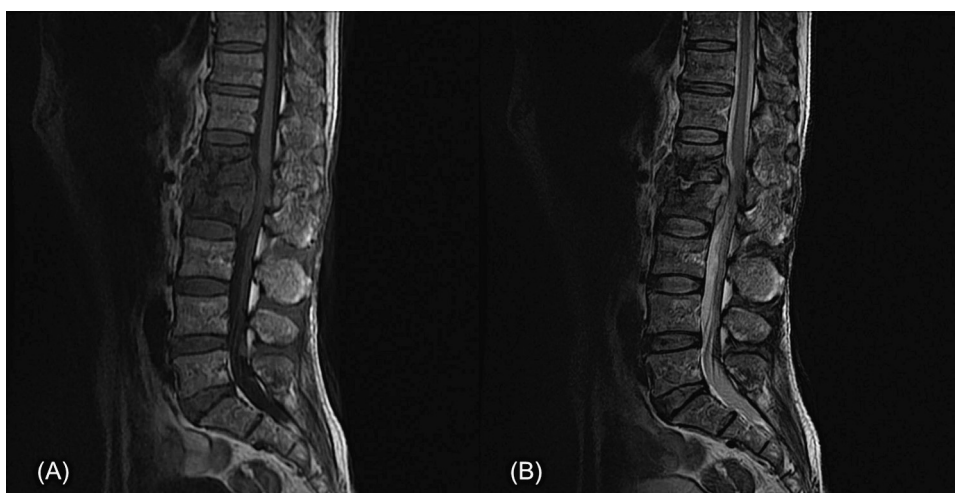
MRI scan of one patient with lumbar spinal tuberculosis showing that the L₁₋₂ vertebral bodies are irregularly destroyed and the dural sac is compressed. T1WI; the focus shows low signal (A). T2WI; the focus shows uneven high signal (B).
